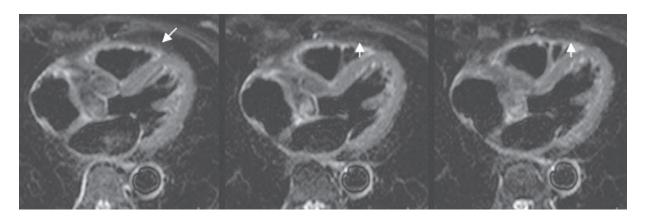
T1W black blood MRI images reveal fibro-fatty replacement (myocardial tissue = gray intensity, $fatty = white \ band) \ at \ the \ RV \ apex \ (in \ box)$
